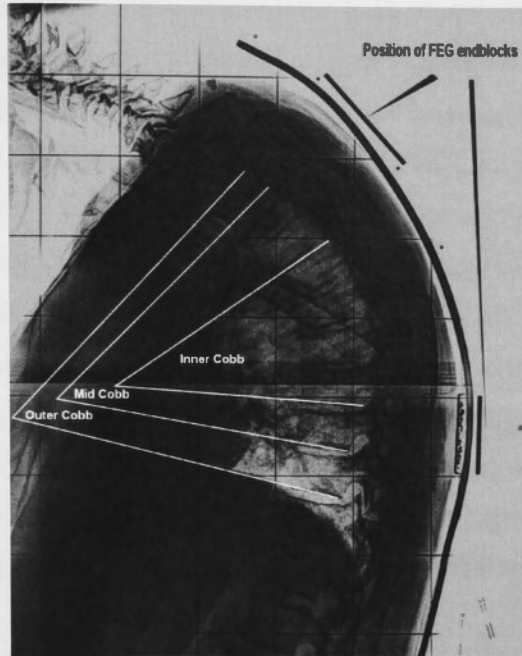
Lateral X-ray of a subject with a flexible electrogoniometer (FEG) attached to his back. The positions of the upper and lower end-blocks are indicated by braces. The end vertebrae used to measure the inner, mid and outer-Cobb angles were determined by their relation to the end-blocks. A flexicurve ruler is shown at the surface of the skin.
